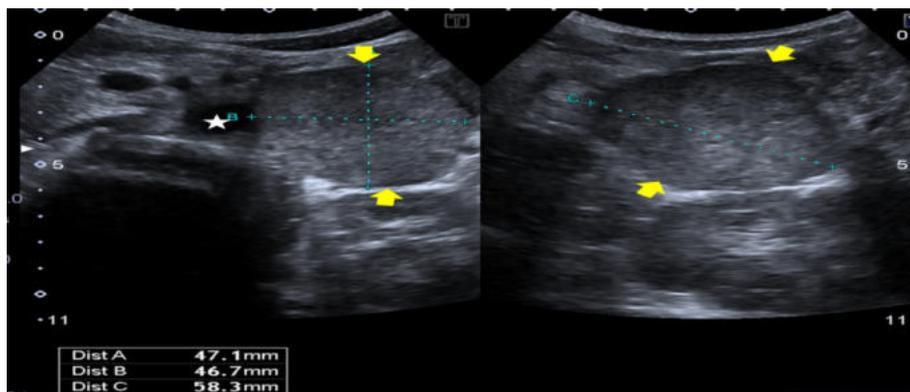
Hypo-isoechoic solid mass image of 47×46×58 mm in the paraaortic area, adjacent to the left kidney lower pole in abdominal ultrasonography.
